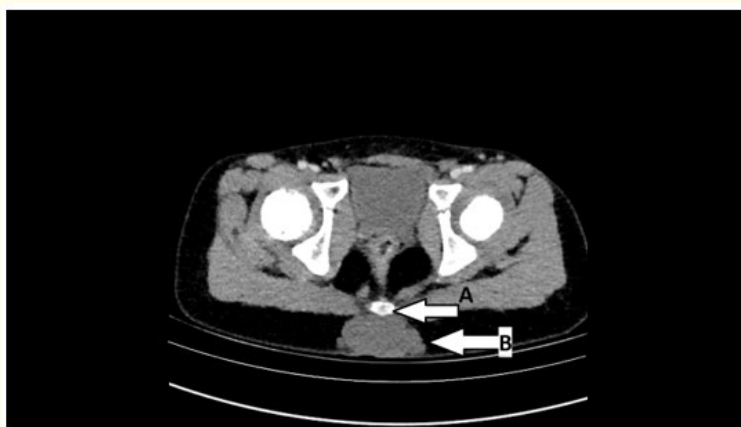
Preoperative CT scan. A. Coccygeal bone B. Tumor.
